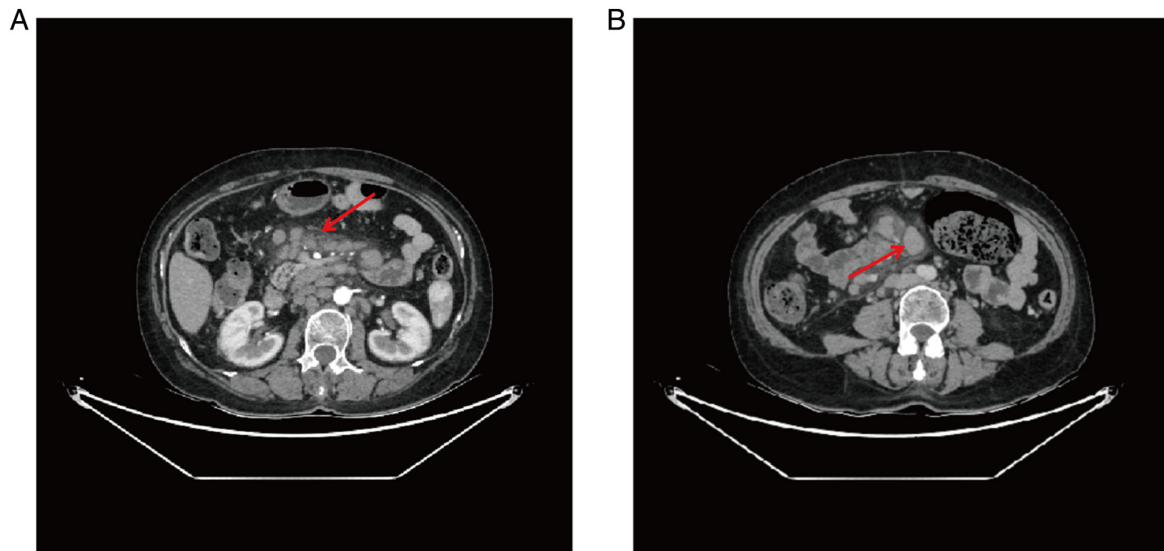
Contrast-enhanced abdominal computed tomography showing multiple enlarged lymph nodes in the abdominal and pelvic cavities (red arrows). (A) Enlarged lymph nodes in the upper abdominal region. (B) Enlarged lymph nodes in the pelvic cavity. The largest node measured $\sim 4.7 \times 2.4$ cm and demonstrated mild enhancement.
